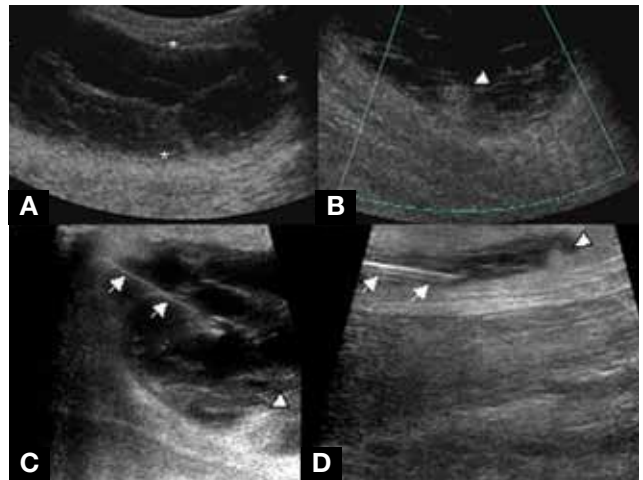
(A) Ultrasound of right thigh in a patient with a painful palpable mass after a cycling accident shows large complex septated fluid collection within deep subcutaneous tissues (asterisks), consistent with a Morel-Lavallée lesion. (B) Internal vascular flow is lacking, according to color Doppler interrogation. (C) Ultrasound-guided aspiration with 20-gauge spinal needle (arrows) yielded 85 cm³ of serosanguinous fluid. (D) Entrapped fat lobules appear as “bright” hyperechoic nodules within lesion (arrowheads) in B and C.
